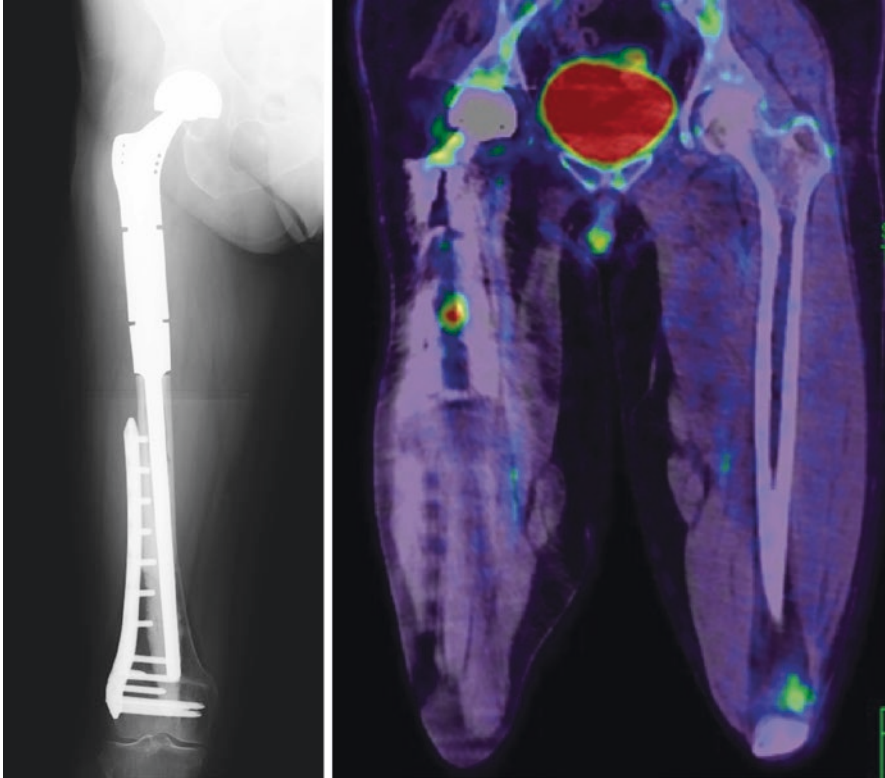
Dedifferentiated chondrosarcoma of the right femur. X-ray of the removed recurrent tumor and reconstruction of pasteurized bone and implants. Local recurrence in the periphery of an implant can be detected via PET/CT
